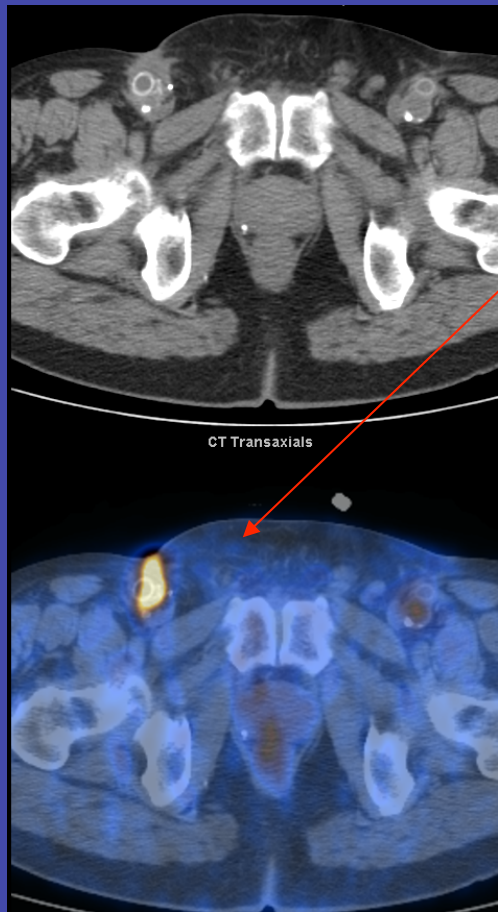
Fifty-eight-year-old male patient, who suffered Q-fever (*Coxiella burnetii*) causing an infected aorto-iliac Dacron prosthesis, which had been inserted seven months before during exclusion of an inflammatory abdominal aortic aneurysm (A. CT image, B. PET image, and C. Fused PET-CT).
